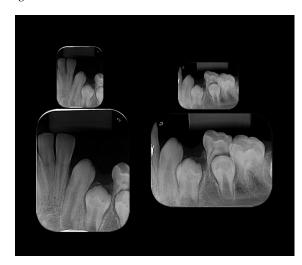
X-ray Periapical Final.
